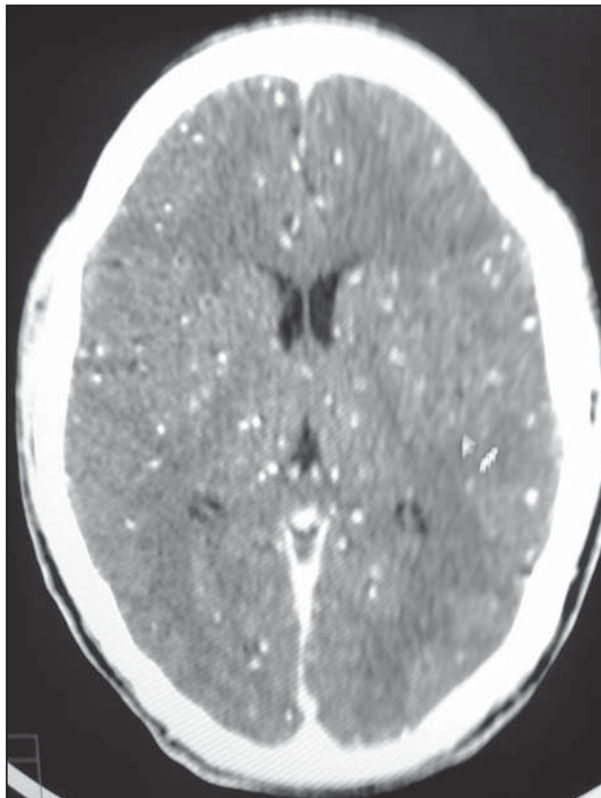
Contrast enhanced CT scan of brain at the level of lateral ventricles shows multiple neurocysticerci in varying stages, studding the entire brain parenchyma. There is no hydrocephalus
